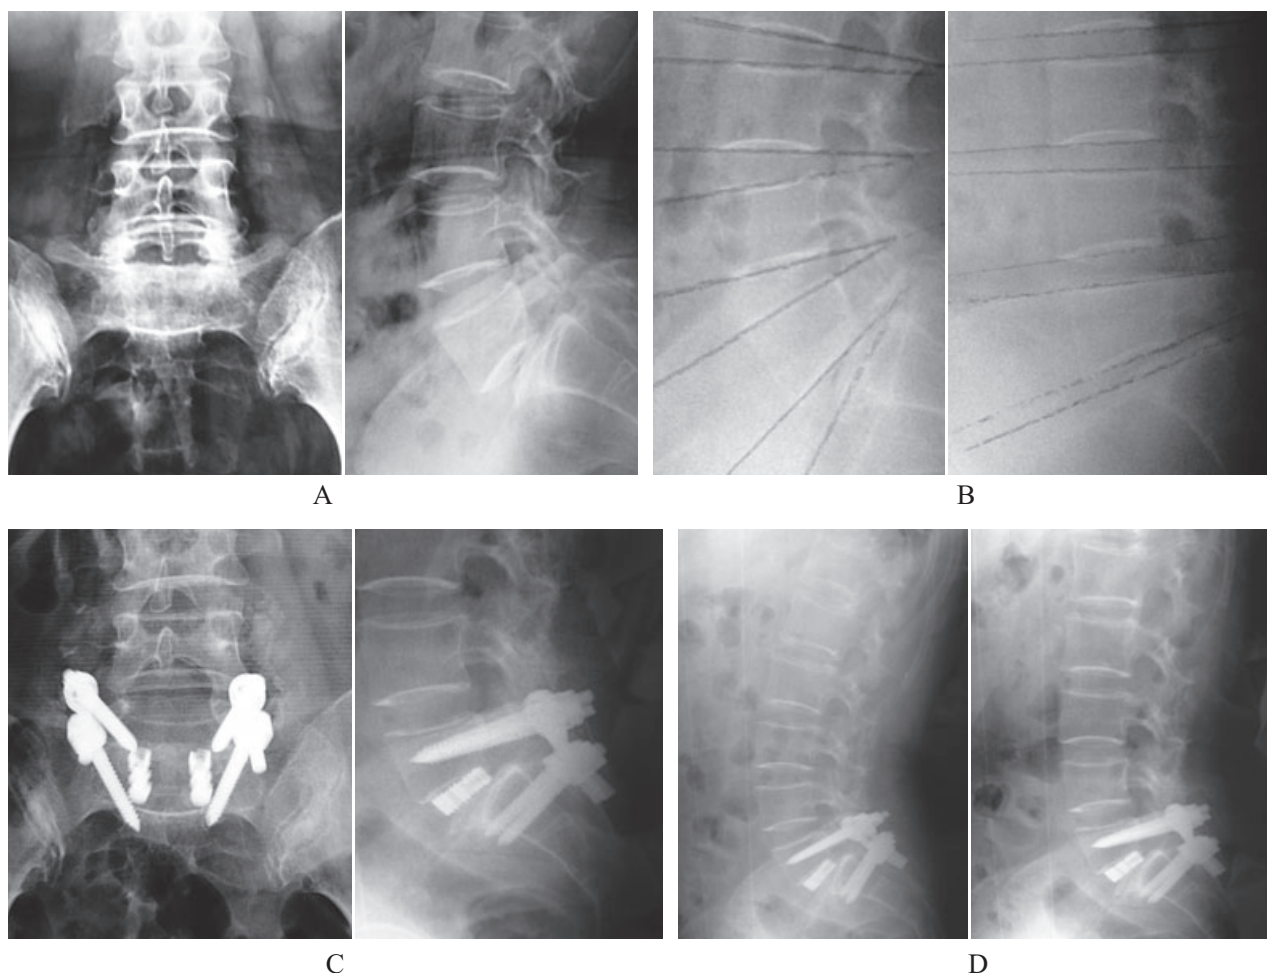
(A) Preoperative radiographs of a 40-year-old woman with symptomatic grade II isthmic spondylolisthesis. (B) Preoperative F-E lateral radiographs show segmental instability in L5/S1. (C) Post-operative radiographs after treatment by PLIF using the titanium-coated fusion system. (D) F-E lateral radiograph at 2-year follow-up show the fused segment is stable.
